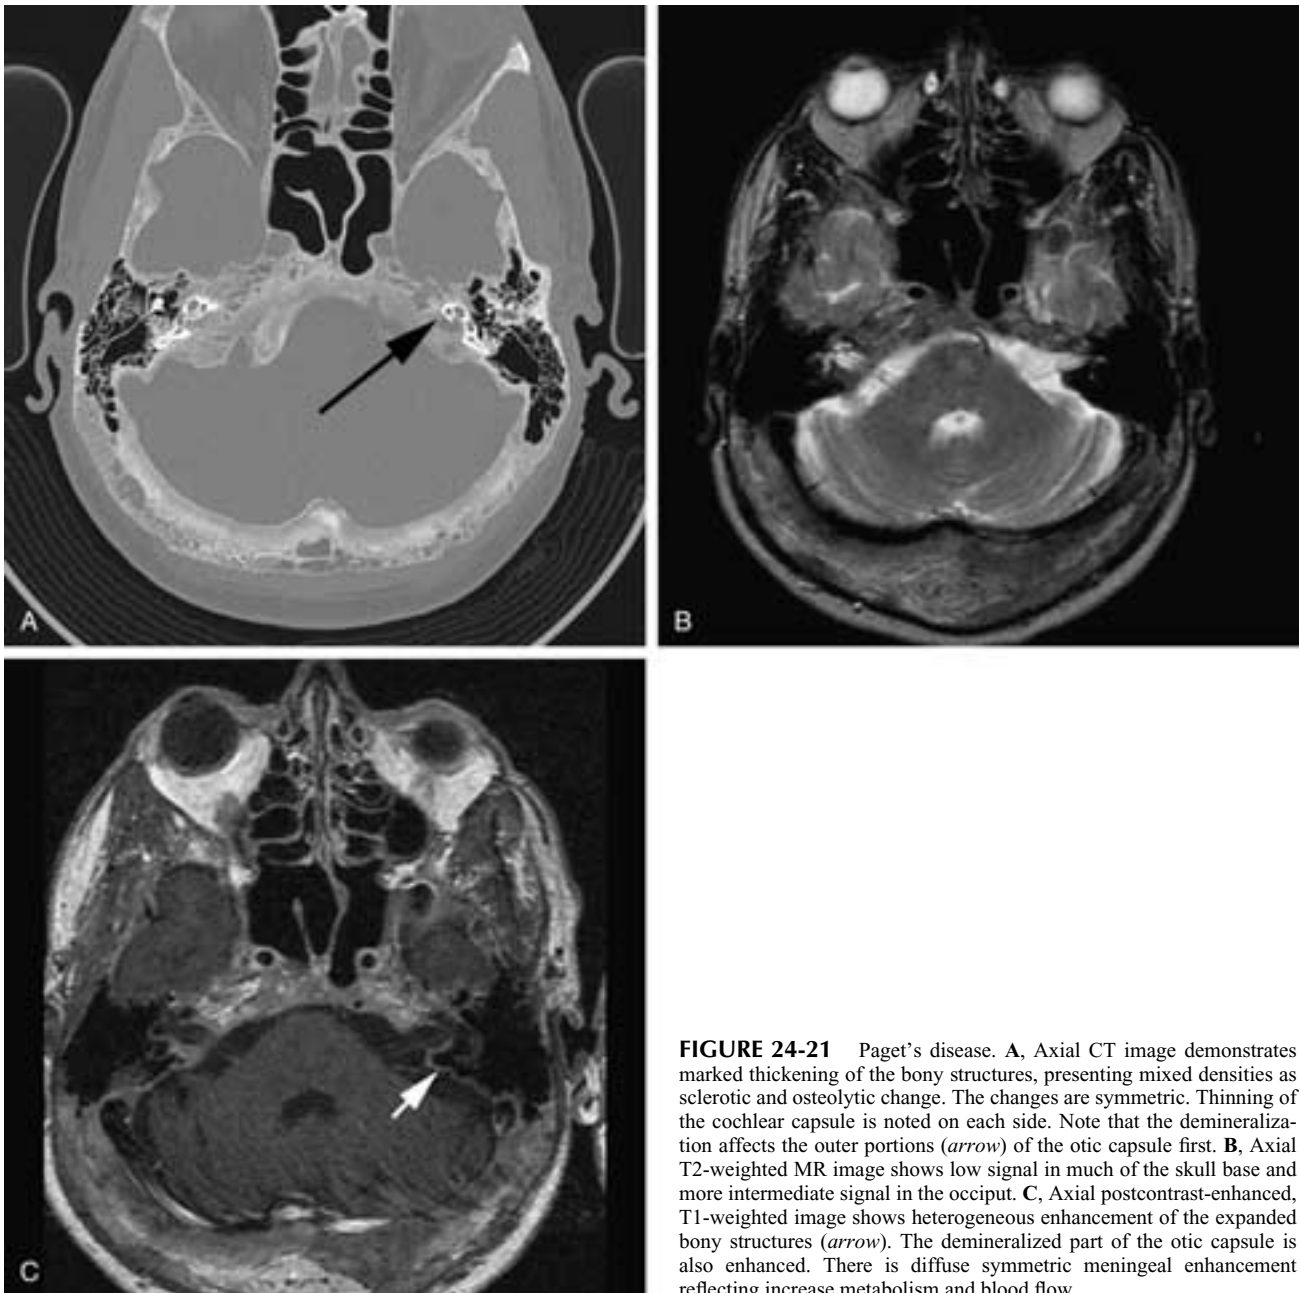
Paget's disease. A, Axial CT image demonstrates marked thickening of the bony structures, presenting mixed densities as sclerotic and osteolytic change. The changes are symmetric. Thinning of the cochlear capsule is noted on each side. Note that the demineralization affects the outer portions (arrow) of the otic capsule first. B, Axial T2-weighted MR image shows low signal in much of the skull base and more intermediate signal in the occiput. C, Axial postcontrast-enhanced, T1-weighted image shows heterogeneous enhancement of the expanded bony structures (arrow). The demineralized part of the otic capsule is also enhanced. There is diffuse symmetric meningeal enhancement reflecting increase metabolism and blood flow.
